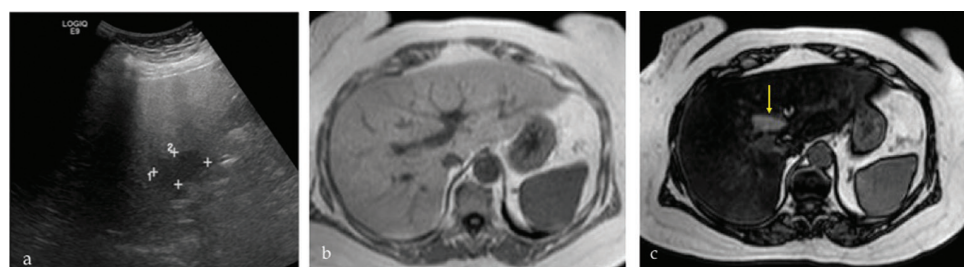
Focal fatty sparing. a. Ultrasound shows an echogenic fatty liver with a triangular area of sparing in the periportal region. b. In and (c) out of phase magnetic resonance imaging of the same case shows marked out of phase signal loss in the background liver with a triangular area of high signal as a result of focal fatty infiltration.
